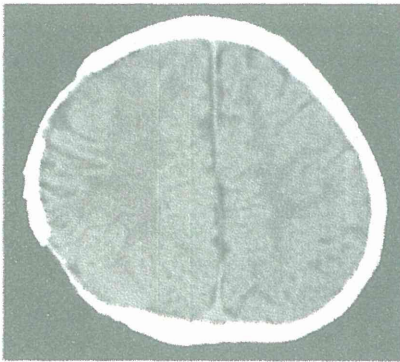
Axial plain CT showing the expansion of the cerebral hemisphere and smooth bonding of the edge
